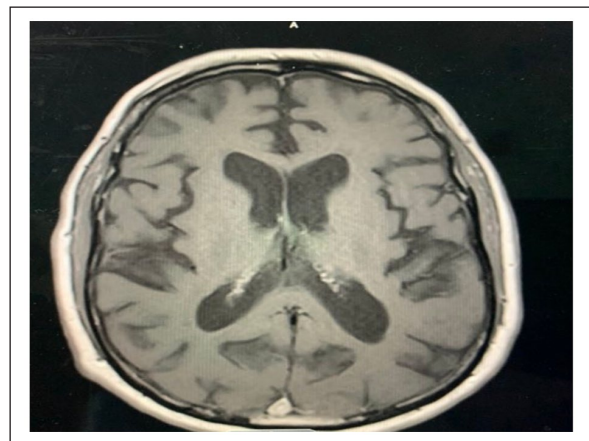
T1-weighted FLAIR MRI scan of the head (axial) showing normal findings.
